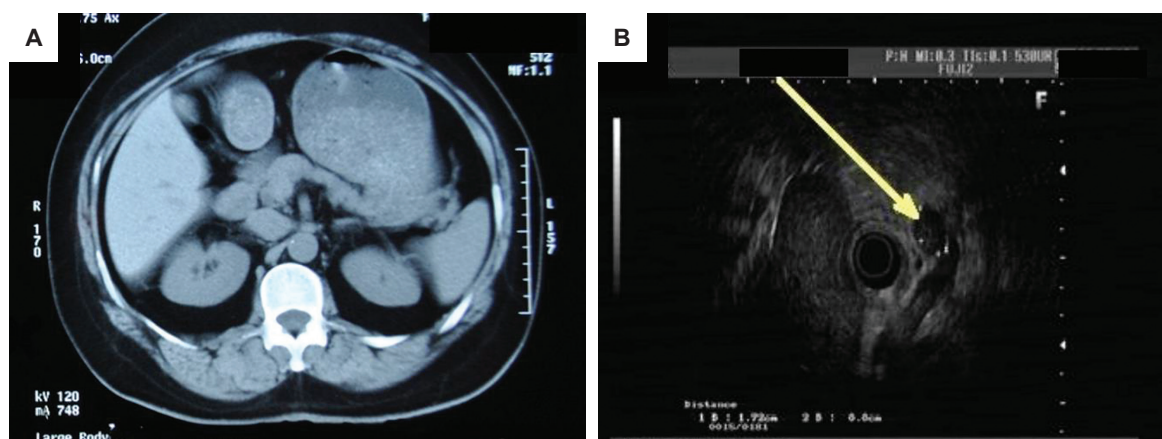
(A) Plain abdominal CT scan did not reveal pancreatic mass. (B) Endoscopic ultrasound showing a pancreatic head tumor (yellow arrow).
